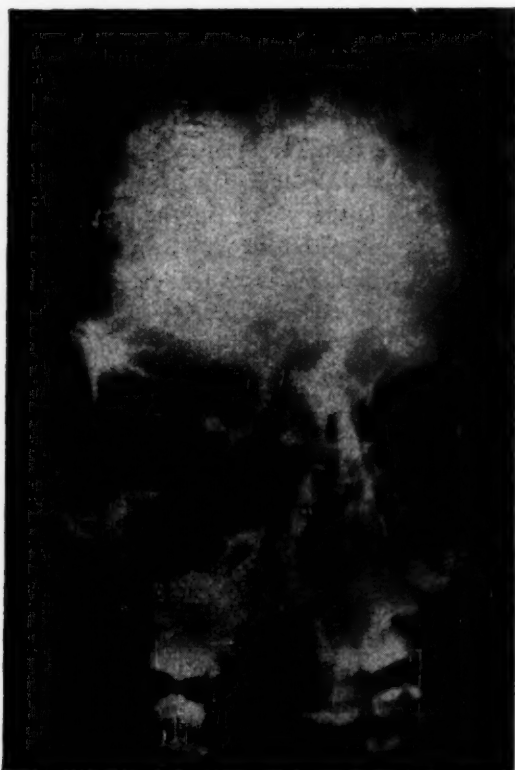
(Newell). Case 1. X-ray study of ethmoidal osteoma involving left orbit.
